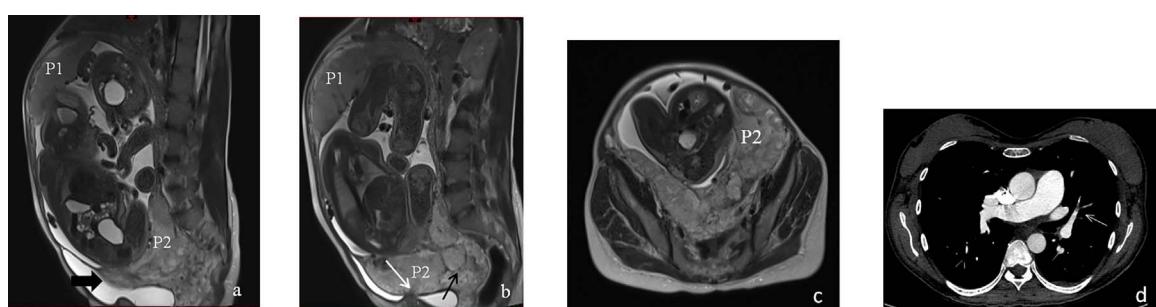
PP and percreta.- 28 y.o. patient with 2 prior cesarean deliveries. The sagittal (a, b) and axial (c) T2-W MR images at the 36th w. of a twin pregnancy show the placenta previa of the second fetus (P2), entirely covering the internal uterine os (fine black arrow, b). Compared to the normal placenta of the first fetus (P1), P2 is markedly heterogeneous (b, c). Note the tethering of the bladder dome (white arrow, b) and the infiltration of the bladder dome (thick black arrow, a), confirming a placenta percreta. Despite prophylactic insertion of bilateral iliac angioplasty catheters before delivery, severe intrapartum hemorrhage required urgent hysterectomy. The patient developed a lung embolism 4 days after delivery, showed in this axial contrast enhanced computed tomography scan image (white arrow, d).
